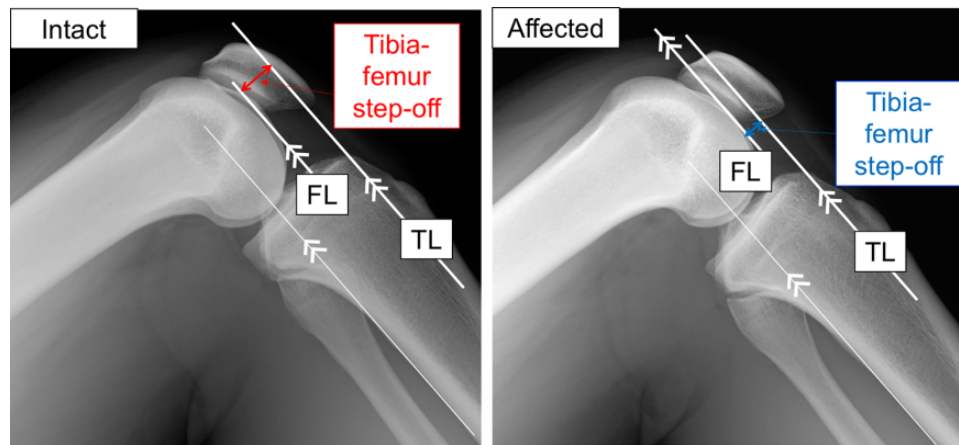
Evaluation of posterior laxity on the gravity sag view of lateral radiographs. The side-to-side difference of the tibia-femur step-off, the interval between TL and FL, was defined as the posterior laxity. FL, femoral line: parallel to the tibial axis and across the middle point between the distal borders of the lateral and medial condyles; TL, tibial line: parallel to the tibial axis and across the anterior border of the tibial third plateau.
